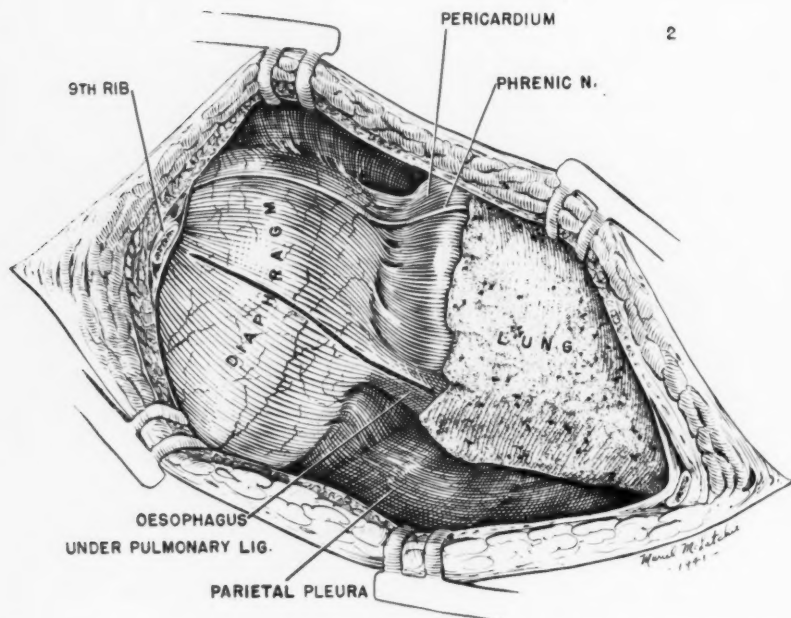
Transthoracic approach to the stomach—anatomy of the field of operation before incision of the diaphragm.
